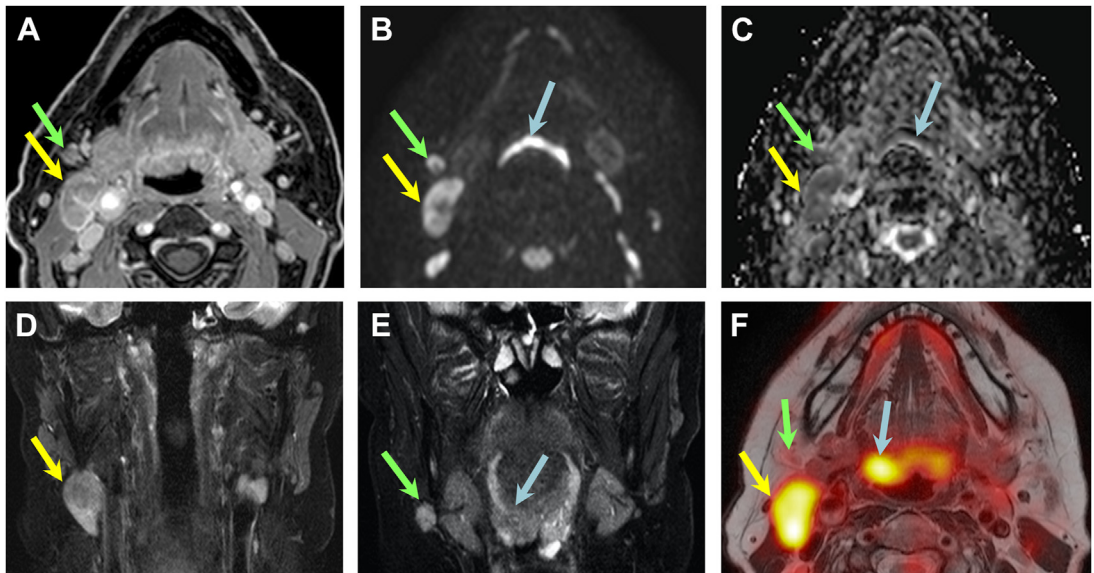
PET/DWIMR imaging features of metastatic lymph nodes seen in a patient with NCUP. (A) Contrast-enhanced Dixon sequence. (B) b 1000 image from DWI. (C) ADC map from DWI. (D, E) Coronal STIR images. (F). Fused PET and T2W image. The patient presented with a level II palpable node (yellow arrows) which has the characteristic features of a metastatic lymph node (increased size, restricted diffusion with $ADC = 0.85 \times 10^{-3} \text{ mm}^2/\text{s}$, inhomogeneous enhancement and increased FDG uptake, $SUV_{\text{max}} = 16$). The smaller level Ib node on the right (green arrows) is suspicious on MR imaging (rounded shape, irregular contour, low ADC, and inhomogeneous enhancement) but shows no FDG uptake due to its small size. On (F), a lesion is seen in the right base of the tongue (blue arrows), which was retrospectively also identified on the coronal STIR (E). Owing to geometric distortion on DWI, the base of the tongue lesion is not seen. Biopsy-revealed HPV-negative SCC in the base of the tongue. Ultrasonography-guided fine needle aspiration cytology (US FNAC) of level II and level Ib nodes was positive for SCC.
